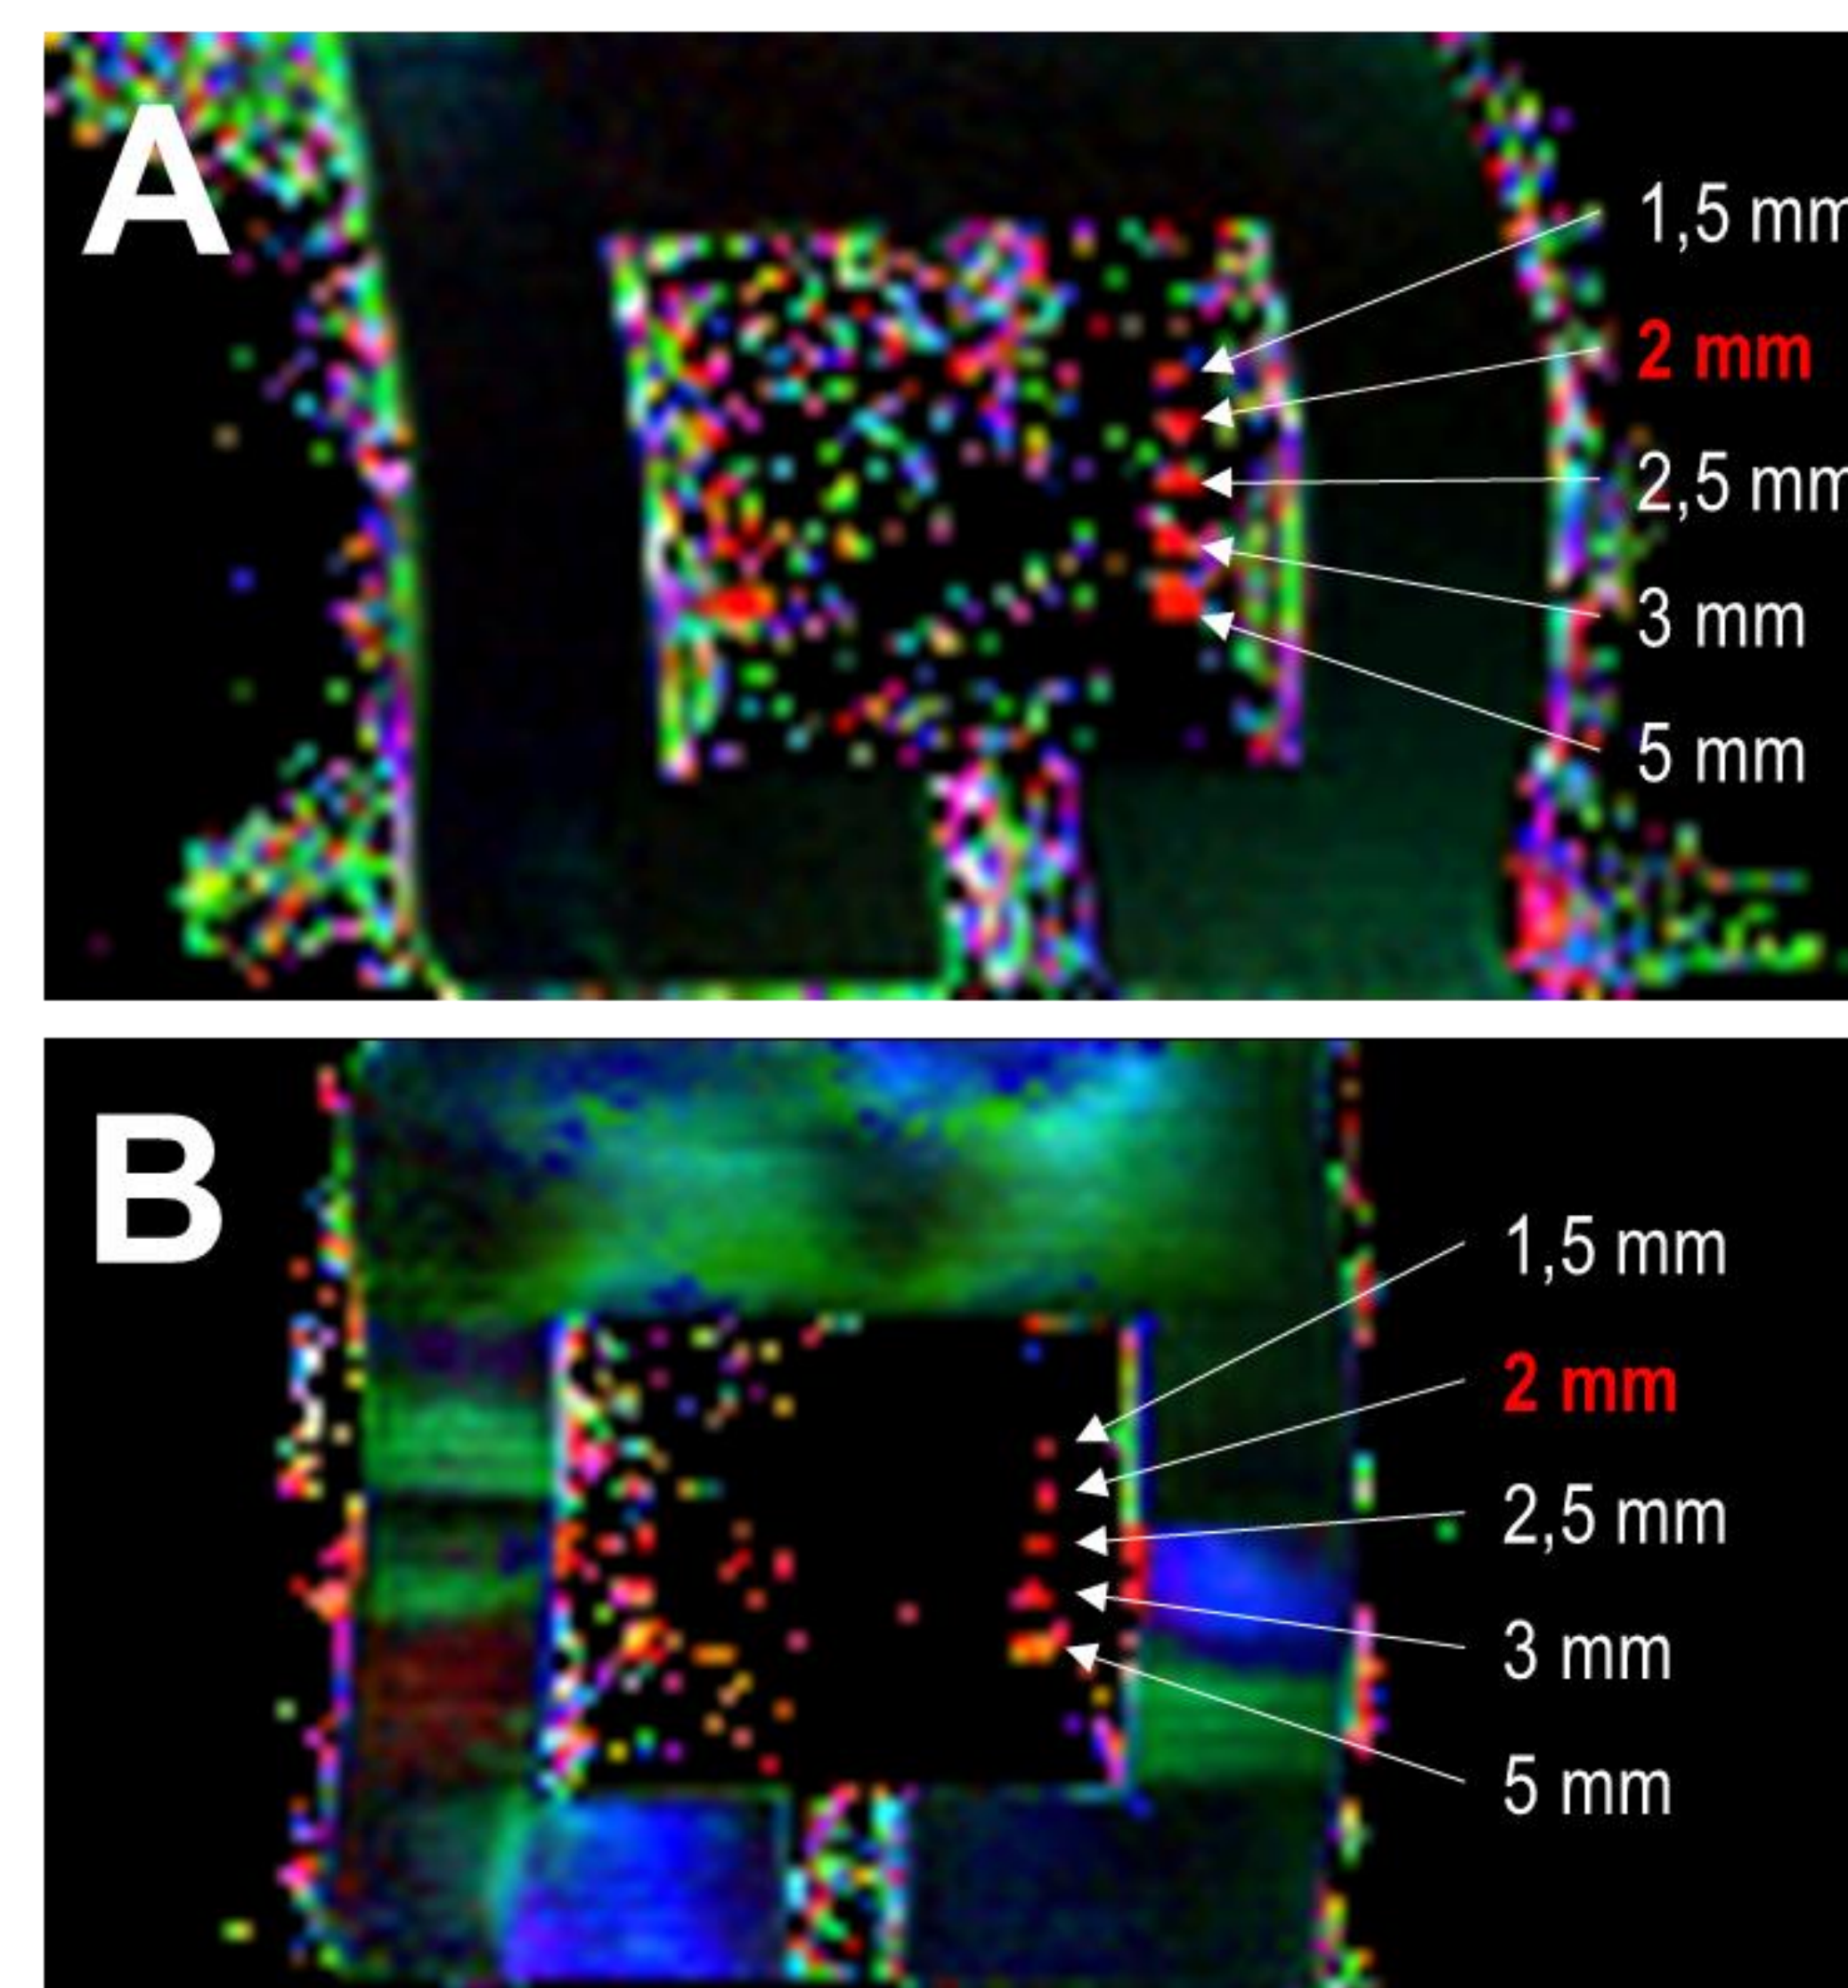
Results of the spatial resolution characterization with the DTI resolution test object on the (A) and (B) the 3T and 1.5T MRI scanners respectively
